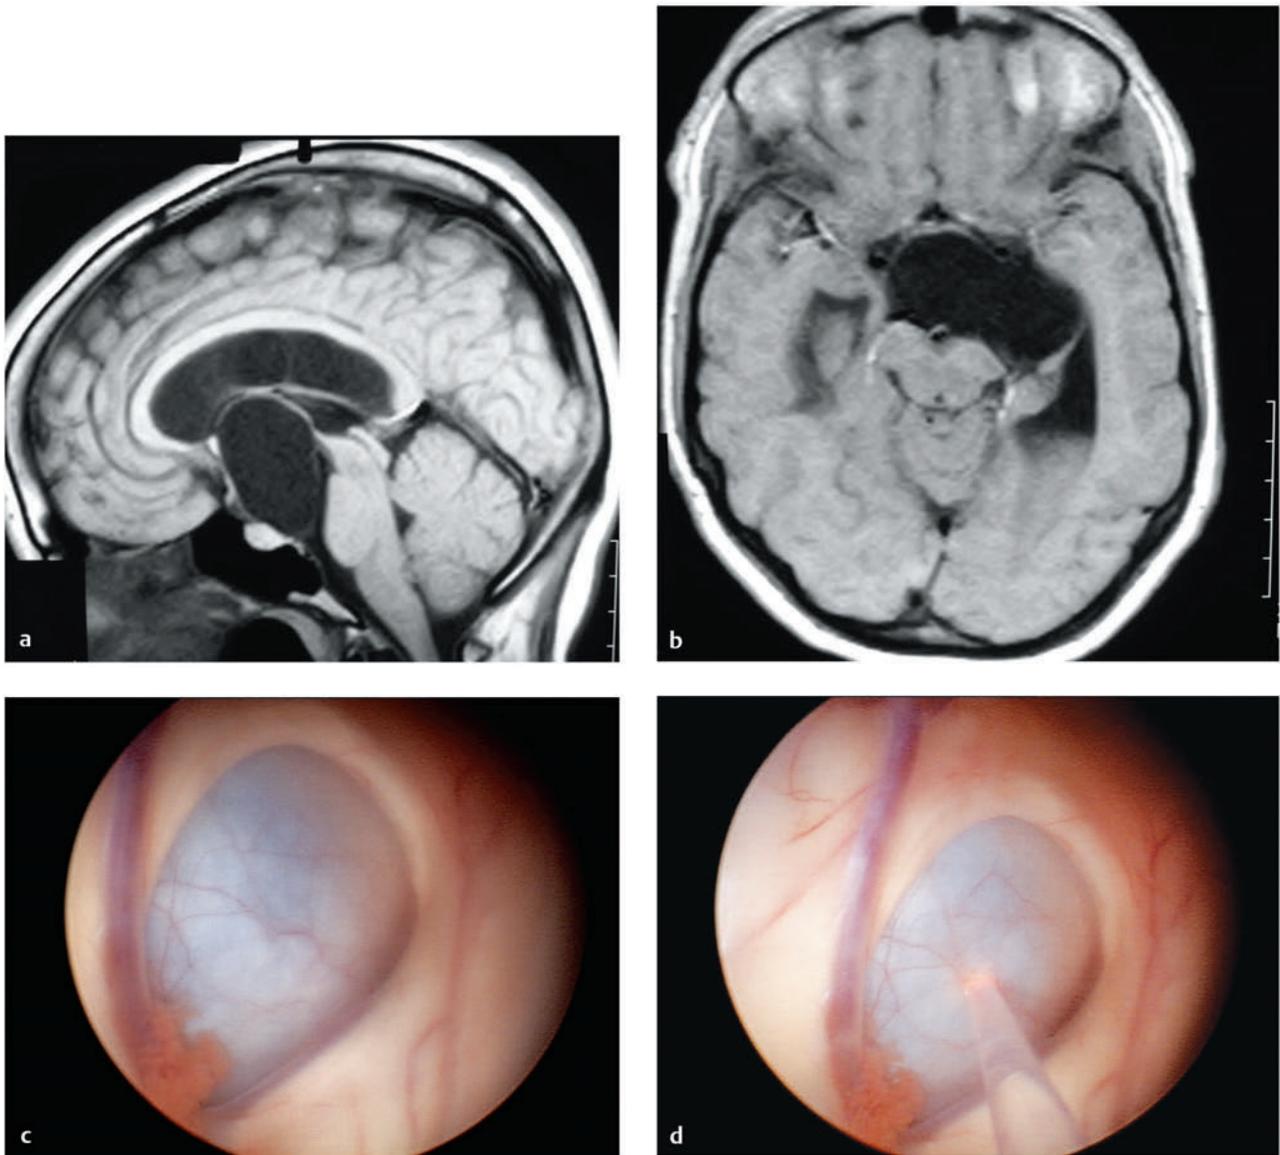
Suprasellar arachnoid cyst. (a) Sagittal T1-weighted noncontrast magnetic resonance (MR) image of a large suprasellar arachnoid cyst with compression on the ventral pons. (b) Axial T1-weighted noncontrast MR image of the same suprasellar arachnoid cyst with compression on the cerebral peduncle. (c) Endoscopic view of the arachnoid cyst with obstruction of the foramen of Monro. The choroid plexus can be seen adjacent to the cyst along with the septal vein that runs along the left side of the image. (d) Endoscopic view of the arachnoid cyst with yttrium–aluminum–garnet (YAG) laser used to fenestrate the cyst wall.
